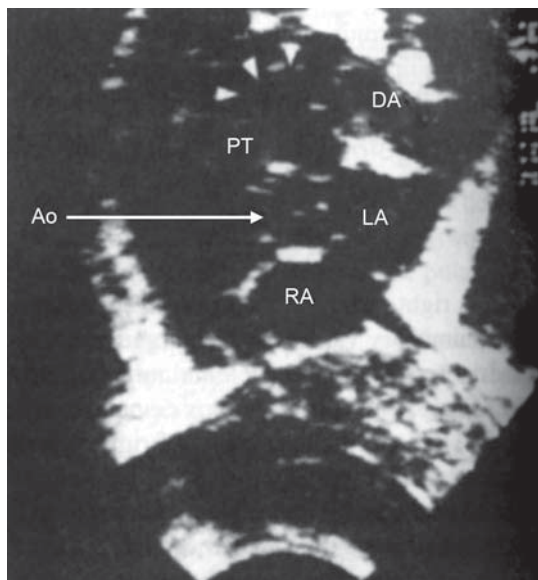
Echocardiography (two-dimensional) in patent ductus arteriosus.
